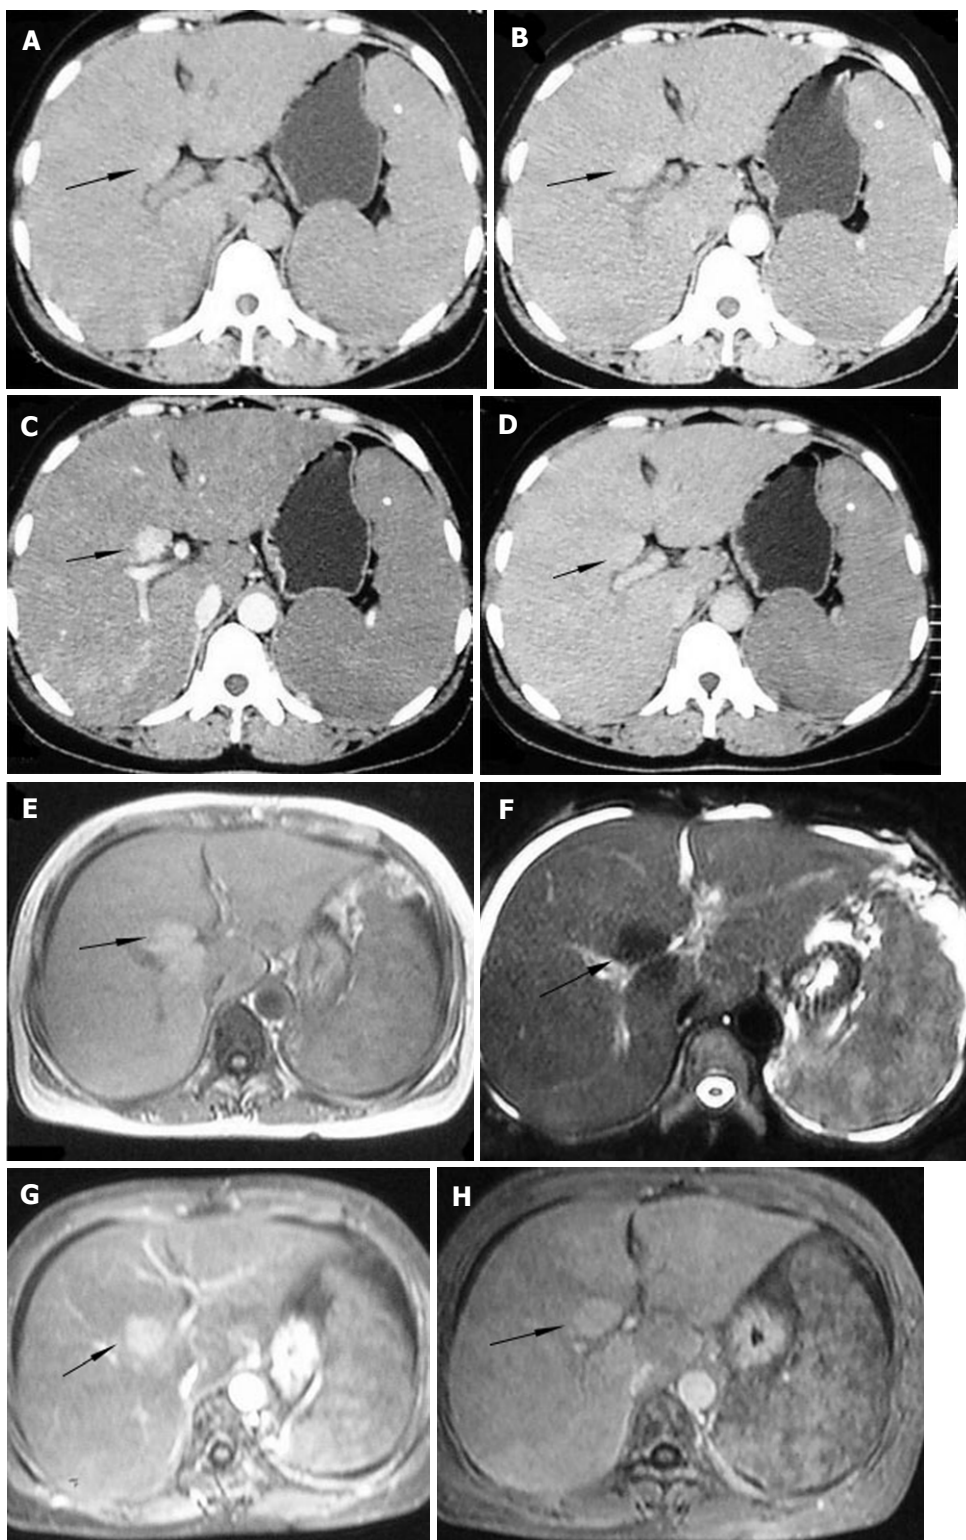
Diffuse hepatic epithelioid hemangioendothelioma in a 48-year-old woman. Plain computed tomography and magnetic resonance imaging manifests an obviously enlarged liver with a large nodule (black arrow) appearing slightly hyperdense relative to normal liver parenchyma (A), isointense on T1WI (E) and hypointense on T2WI (F), with slight enhancement in the arterial phase (B), evident enhancement in the portal venous phase (C and G) and iso-density/intensity in the equilibrium phase (D and H), associated with splenomegaly and ascites (F).
